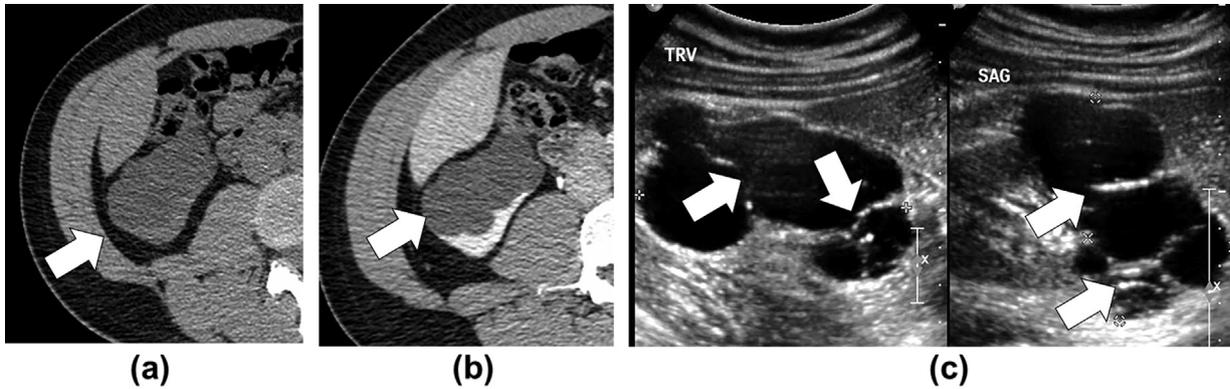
A 46-year-old man with incidentally detected complex renal cyst on ultrasound. CT was performed for further characterisation. (a) Unenhanced and (b) contrast-enhanced axial CT images show a water attenuation lesion in the lower pole of the right kidney (arrows) without any solid component, septa, or measurable enhancement. This lesion was classified as a Bosniak I cyst. (c) Transverse and sagittal grey-scale ultrasound images retrieved from the patient's electronic file revealed multiple complex thick septa (arrow), which were not perceptible on CT. In this example, ultrasound upgrades the Bosniak category compared to CT from Bosniak 1 to 2F or 3.
